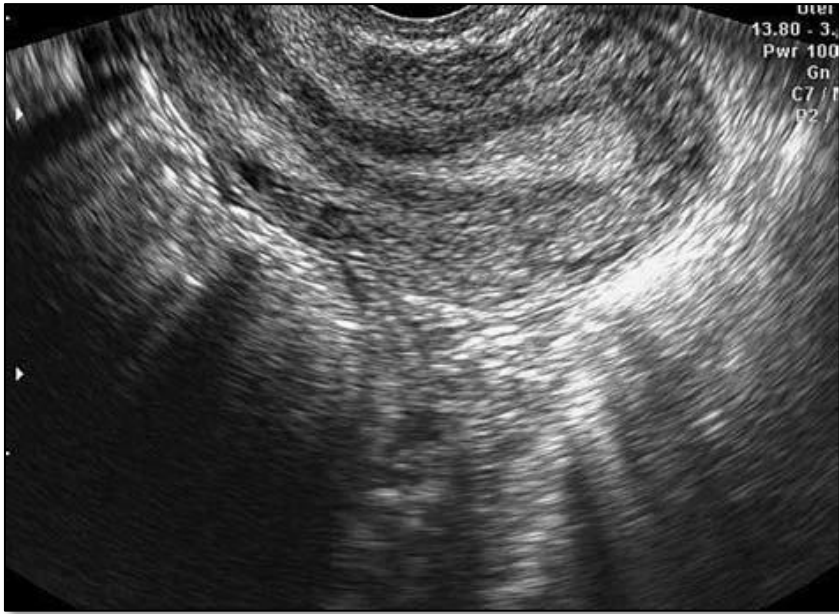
Normal position and internal structure of the uterus on endovaginal ultrasonography (*Quoted from Mihi and Mihi, 2011*).
